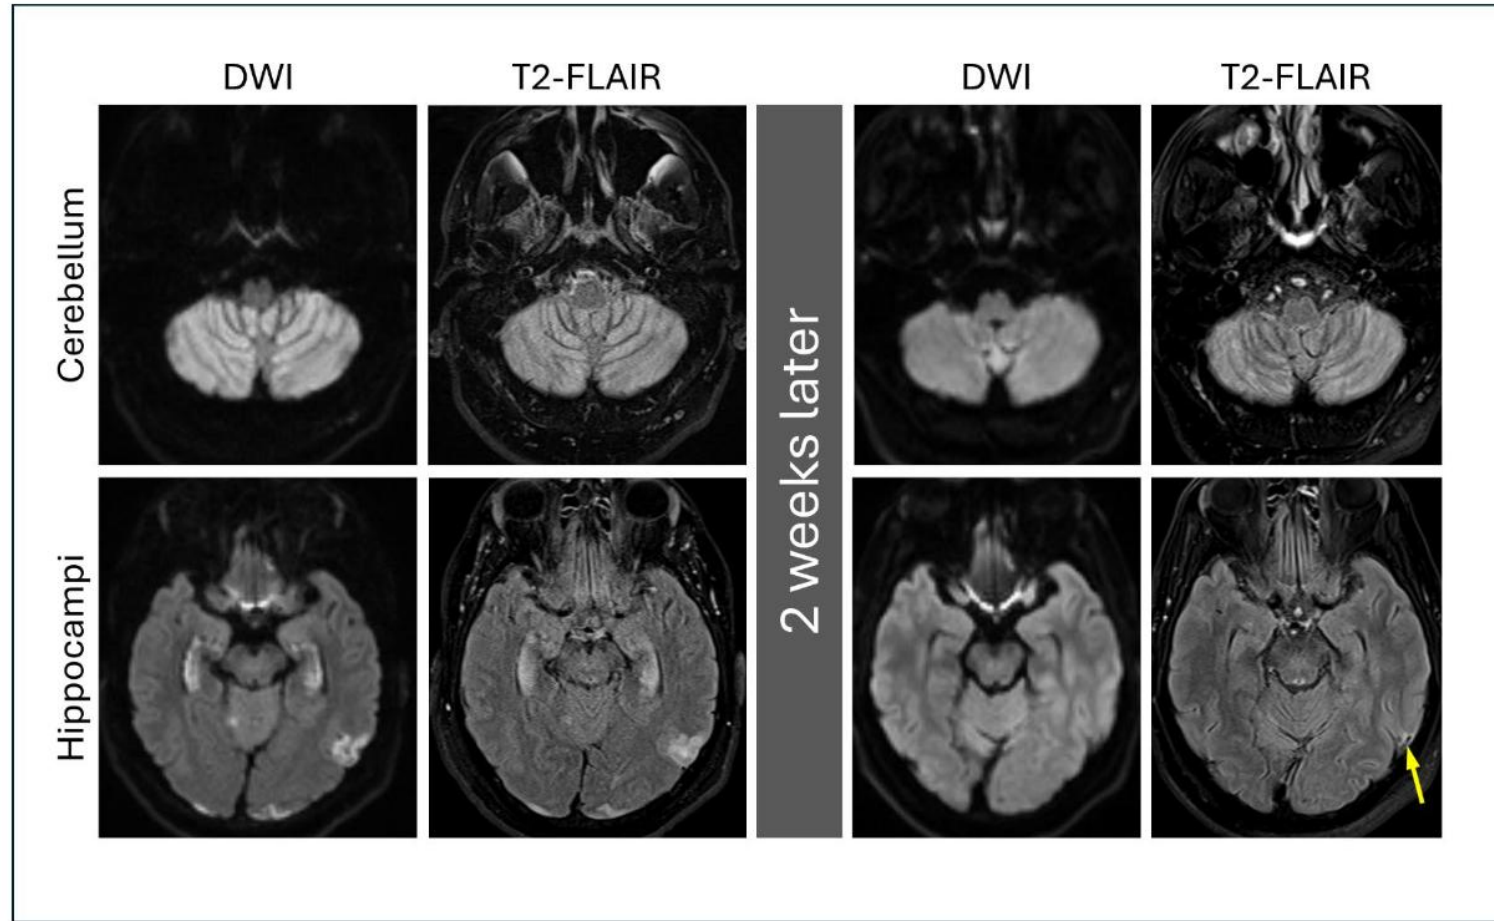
Progression of MRI findings in CHANTER syndrome in the same 58-year-old male patient from Figure 2. Representative DWI and T2-FLAIR axial images are shown at baseline (left) and after 2 weeks (right). Areas of restricted diffusion and T2-FLAIR signal hyperintensity in the cerebellum, hippocampi, and posterior cerebral cortex are less conspicuous on followup imaging with only a small area of developing gliosis in the posterior left temporal cortex (yellow arrow).
